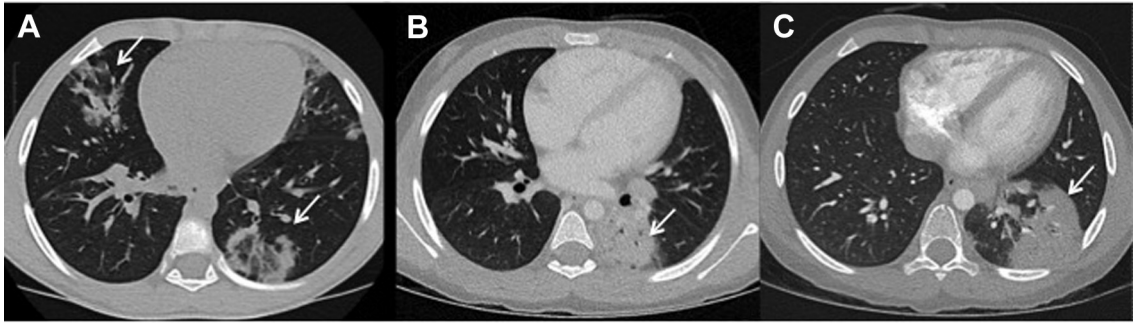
(A) Focal mixed attenuation lung consolidations with the Atoll sign in the left lower lobe and patchy focal consolidations in the right lobe, on initial CT at presentation (arrows); (B) new focal alveolar consolidation with air bronchograms in the left lower lung (arrow), postcorticosteroid weaning (8 months after presentation); and (C) new focal alveolar consolidation with air bronchograms in the left lower lobe at follow-up (6 months after initiation of corticosteroid treatment and 13 months after presentation) (arrow).
